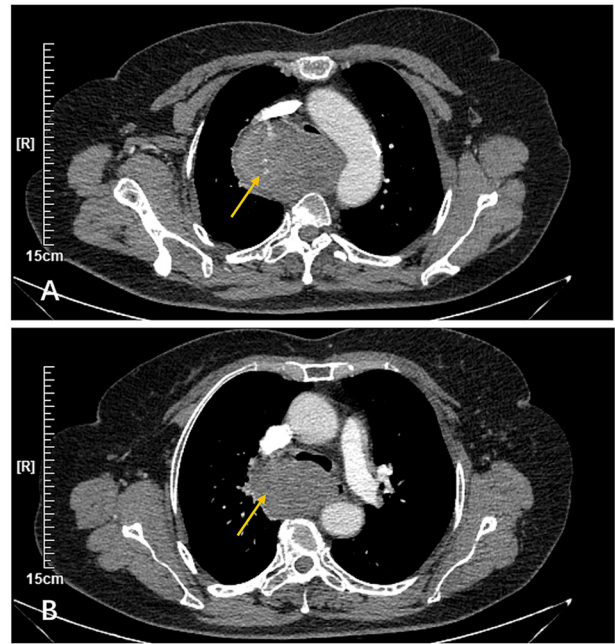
Baseline contrast-enhanced chest computed tomography in January 2022. (A) Maximum cross-sectional area showing a soft tissue mass measuring 8.5x6.2 cm (yellow arrow) at the right posterior upper mediastinum with uneven density and spotted calcification, and a compressed and deformed trachea and esophagus. Inhomogeneous enhancement was observed after injecting iodinated contrast medium. (B) Subcarinal cross-sectional area showing a soft tissue mass measuring 6.6x4.4 cm (yellow arrow).
